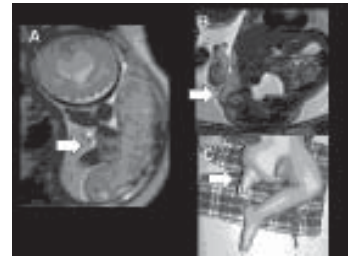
A-C, Fetal MR in musculoskeletal imaging. Figure 8A is a case of club foot. Tracing the limb on contiguous images for assessing alignment shows an inwardly rotated foot. The fetal brain is included in this section and reveals dilatation of the frontal horns. The septum pellucidum is not visualized suggestive of septal agenesis. B, C in a case of Unilateral complete phocomelia shows foot attached to hip. The joint is associated with abnormal soft tissue. The femur, tibia and fibula are absent. C. Photograph after birth confirms MRI findings.
